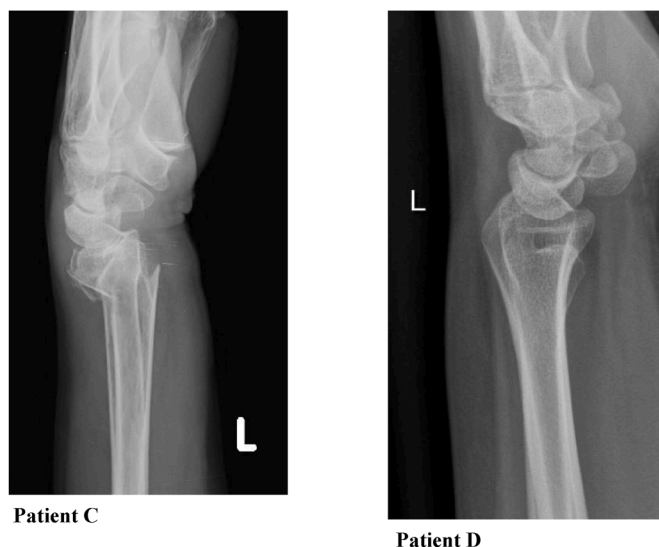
Wrist x-ray comparative images (patient C²⁸ and patient D²⁹).
